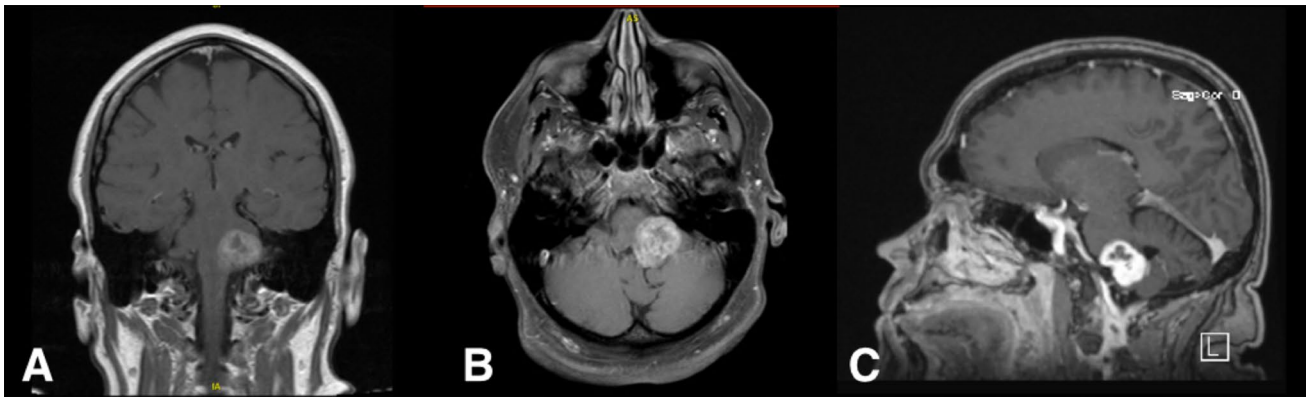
a–c Different sections of an MRI T1 with contrast showing a partially calcified heterogeneously enhancing lesion centered within the left middle cerebellar peduncle with mass effect on the left pons.
